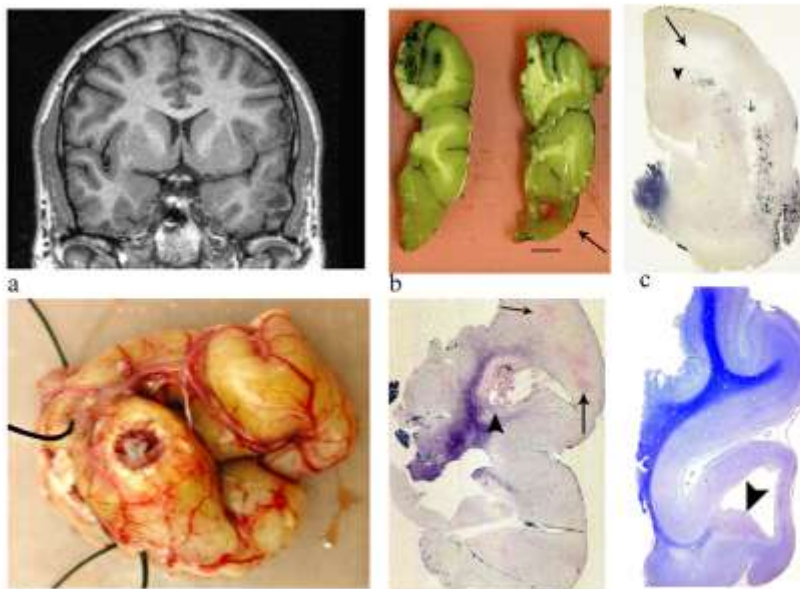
Pathology features of DNT a= MRI features of temporal lobe tumour b= cystic tumour in inferior gyrus (arrow), c= tumour diffusely infiltrating cortex d= calcified DNT abutting cortical surface, e= multinodular DNT, f= section through a cystic DNT.
